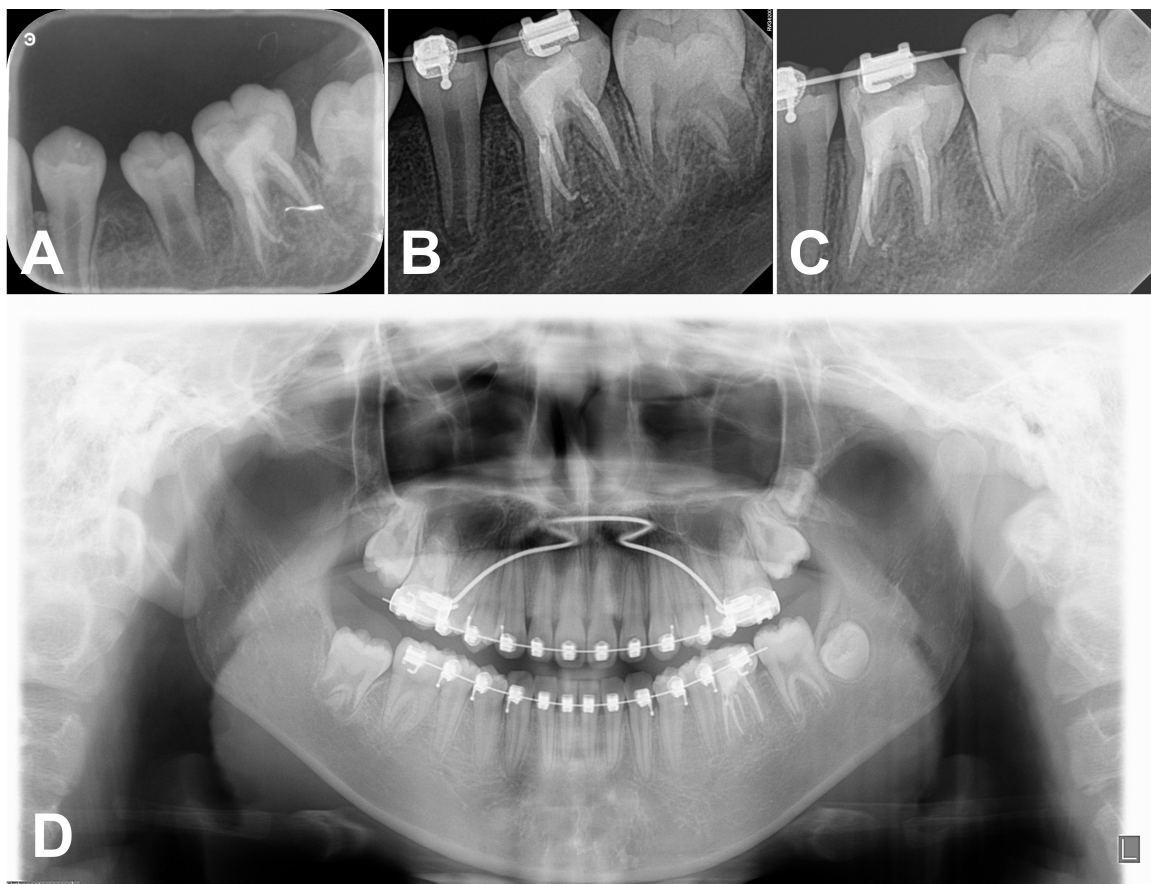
Serial postoperative radiographs. Follow-up radiographs: (A) Periapical, 4-month recall. (B) Periapical, 1-year, 2-month recall. (C) Periapical, 3-year recall. (D) Panoramic, 4-year recall. All images demonstrate normal, healed periapical tissue.
